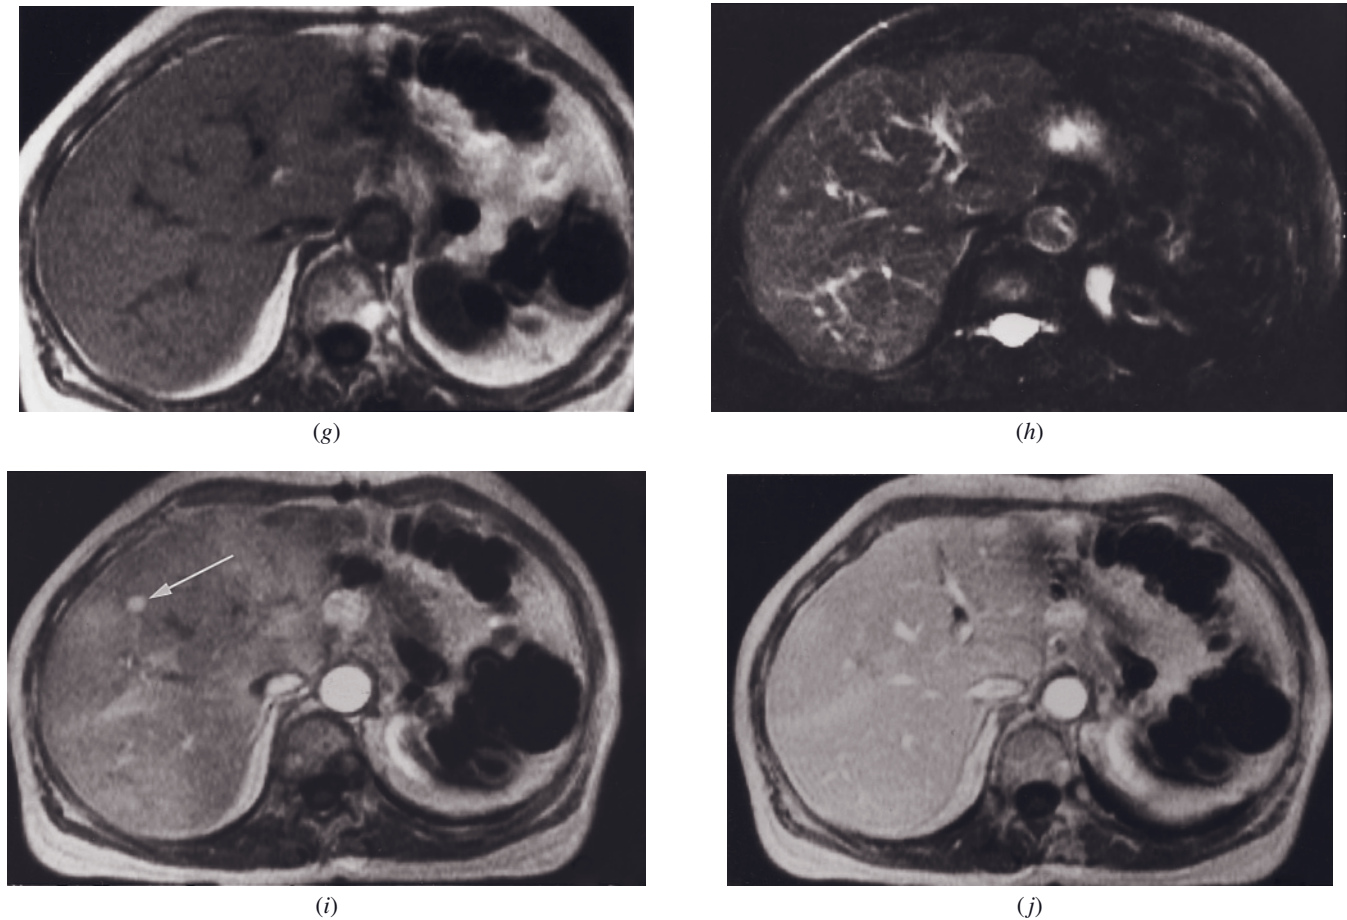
(Continued) of the liver that is not visualized on the CT (*f*) or noncontrast T1-weighted (*g*) or T2-weighted (*h*) images, but is well shown as a uniformly enhancing lesion (arrow, *i*) on the immediate image (*i*). The metastasis washes out rapidly and becomes isointense with liver by 45 s (*j*). Small hypervascular malignant lesions commonly are shown only on hepatic arterial dominant-phase images.
